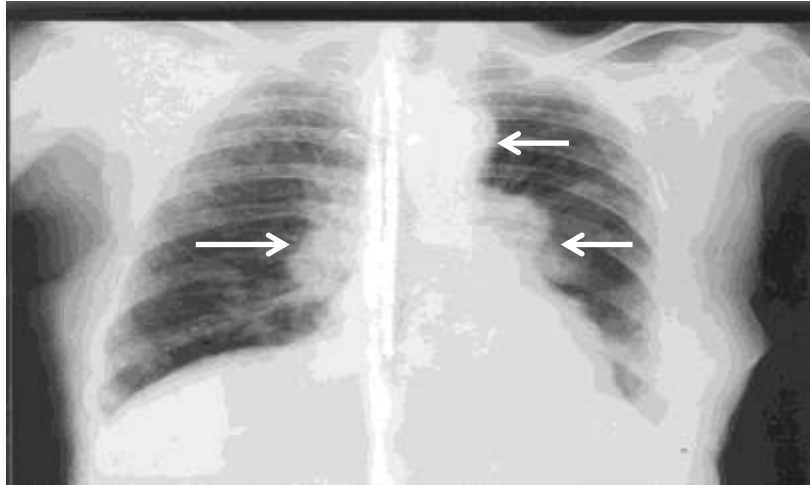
Chest X-ray showing multiple nodular opacities in both lung fields and bilateral dense hilar shadow (white arrows).
